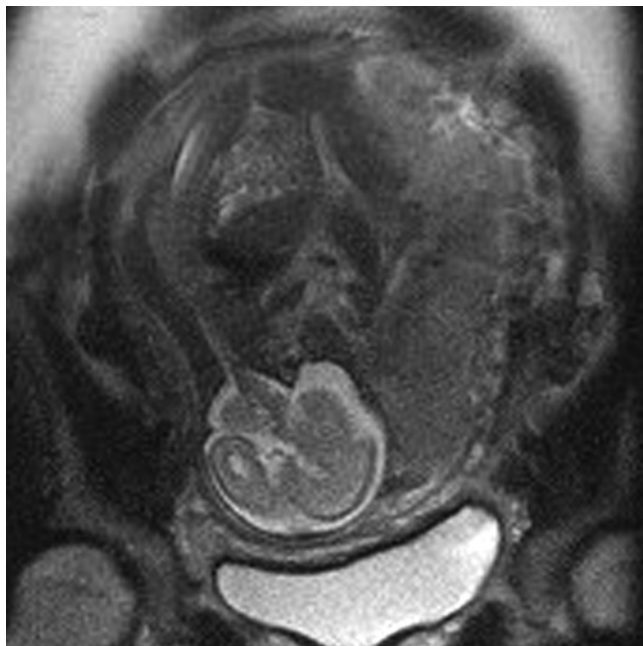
Anhydramnios secondary to renal agenesis. Coronal T2-weighted SS-ETSE image of a fetus at 24 weeks of gestation reveals no visible amniotic fluid. No kidneys could be found.
